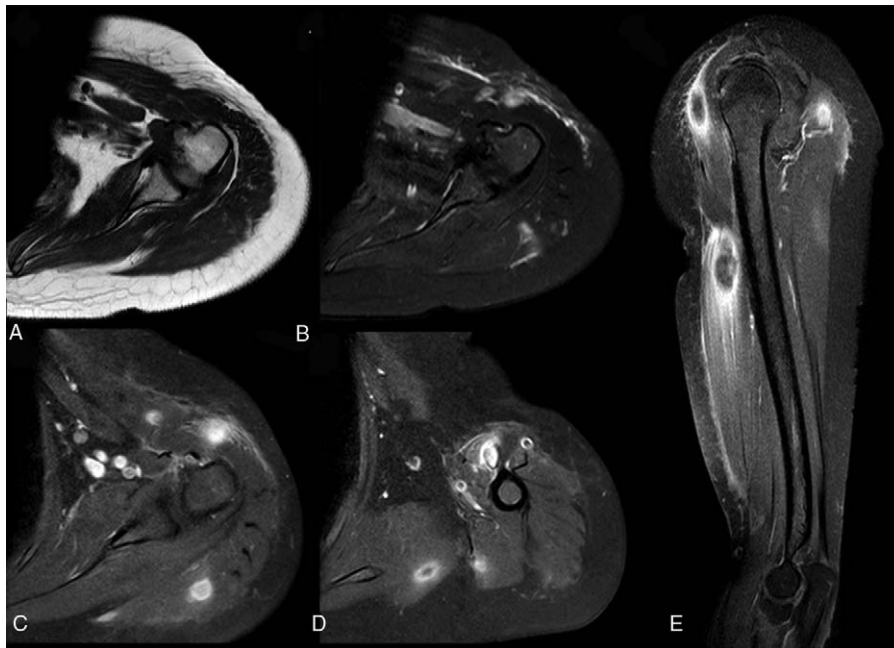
Magnetic resonance imaging of the tumors. (A) A T1-weighted axial magnetic resonance imaging scan showed iso signal intensity. (B) A T2-weighted axial magnetic resonance imaging scan revealed multiple hyperintense. (C–E) Axial and sagittal fat-suppressed contrast-enhanced T1-weighted images identified marked inhomogeneous or rim enhancement mass in pectoralis major, deltoid, biceps brachii, triceps brachii, and teres major muscles.
